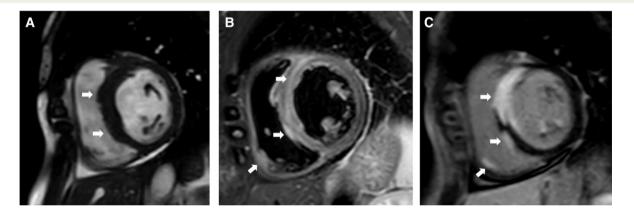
Magnetic resonance images of a patient with cardiac sarcoidosis, 3rd degree atrioventricular block, and normal left and right ventricular ejection fraction. The arrows highlight key findings. (A) short-axis cardiac cine image showing thickened ventricular septum. (B) T2-weighted image showing septal and local right ventricular edema indicating active inflammation. (C) late gadolinium enhancement image showing transmural septal, pap-illary muscle, and local right ventricular free wall involvement.
